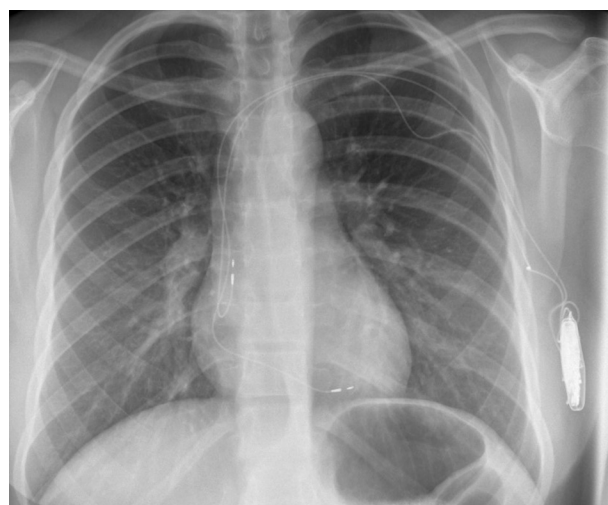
Chest radiograph shows Biotronik Closed Loop Stimulation system, implanted in the axilla.
